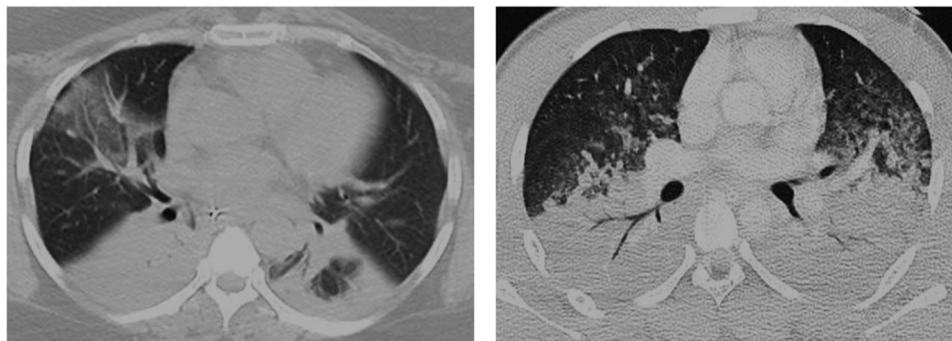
Typical pattern of “pulmonary” (left) and “secondary” (right) ARDS at CT scan.
